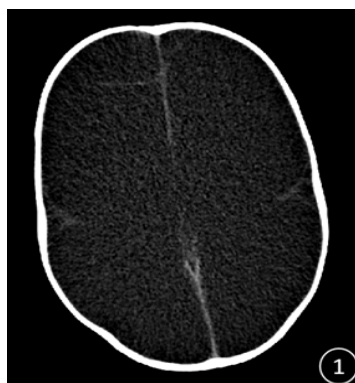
Non-contrast axial CT image shows that both cerebral hemispheres are absent, brain cavity is filled by cerebrospinal fluid, with no visible brain tissue
